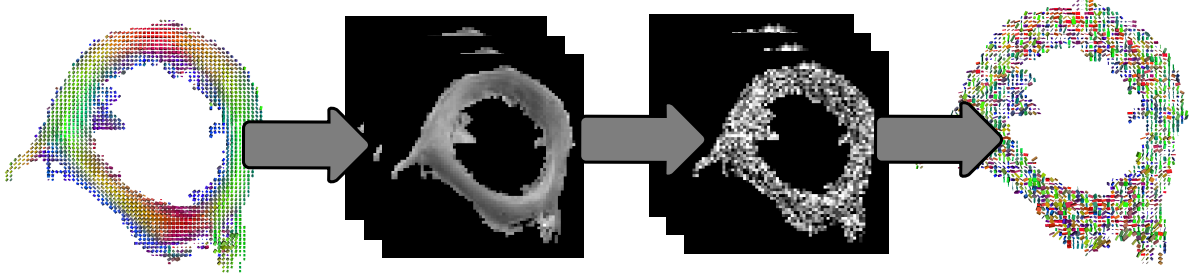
6 Diffusion Weighted Images (DWIs) were artificially computed from the reference tensor field. Each DWI was corrupted by additive Rician noise, and the tensor field was then estimated. The variance of the added Rician noise in this example was  $V = 0.04$  for each DWI, which results in an SNR of 10.0.
